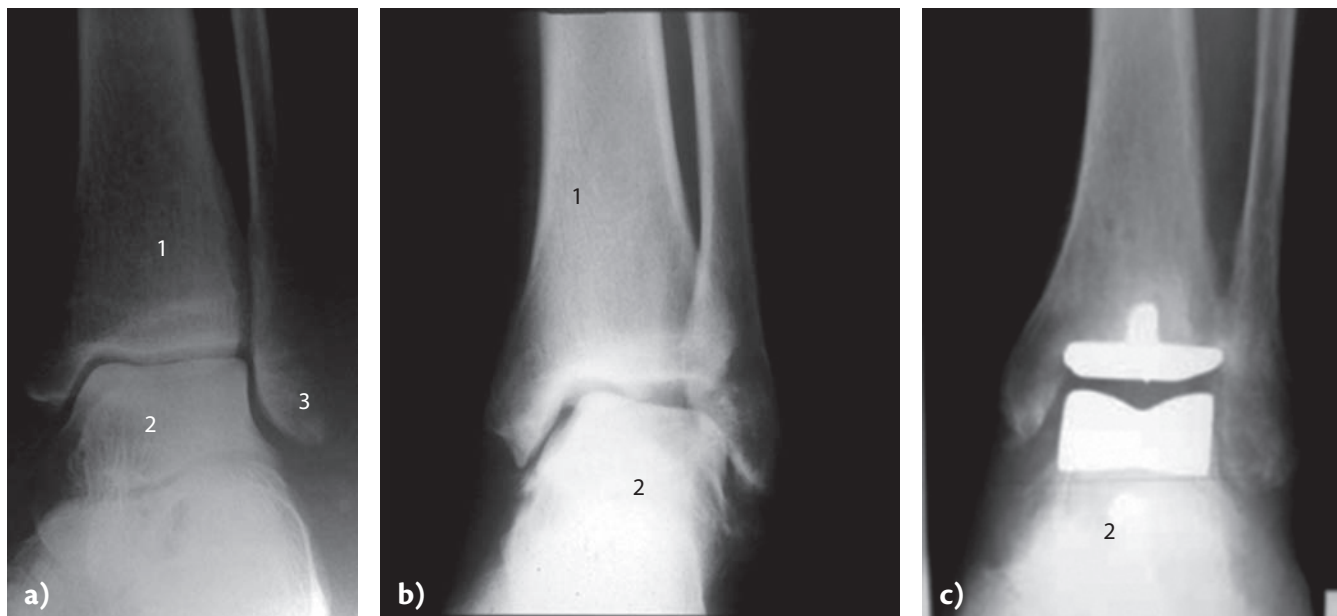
X-rays of osteoarthritis ('worn out' joint) in the ankle. a) Healthy ankle; b) ankle with reduced height of the cartilage, i.e. starting osteoarthritis; c) ankle prosthesis. On average 90% of the prosthesis are still in place and functioning at 8–10 years, after which time new surgery may be needed. 1; Tibia, 2; Talus, 3; Fibula.
